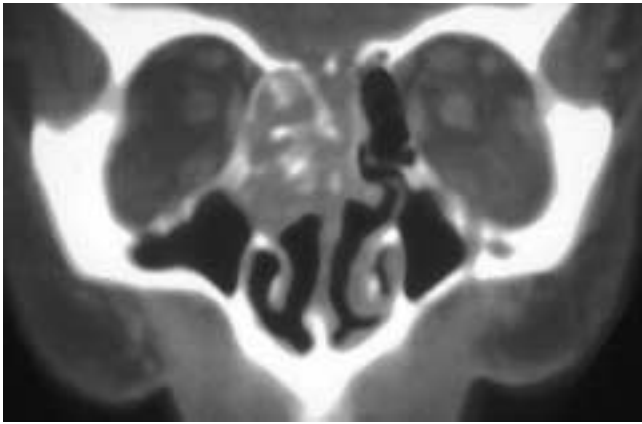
Coronal CT scan shows a right ethmoid sinus and an upper nasal fossa mass. The right lamina papyracea is intact, and there is thinning or erosion of the cribriform plate. There are also apparent calcifications within the tumor. This patient had an inverted papilloma. The radiodensities were pieces of residual bone and not tumoral calcifications.
